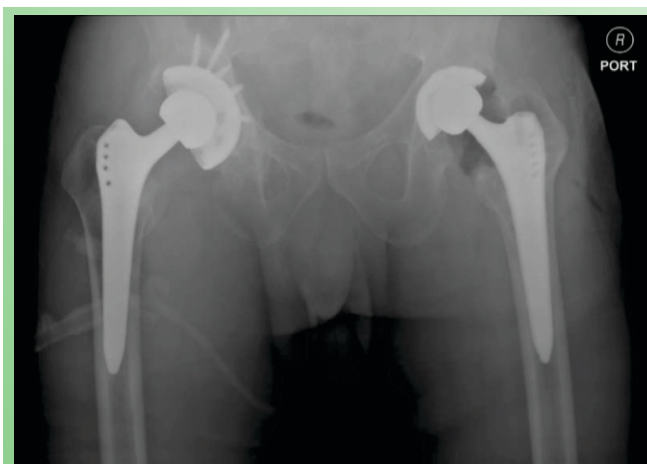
Post-operative Bilateral Hip Radiograph Showing Stable Components.
